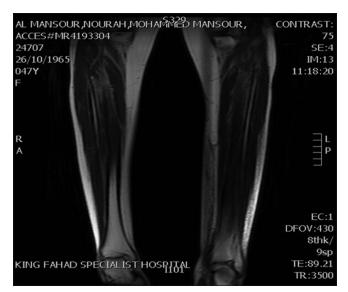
Magnetic resonance imaging tibia/fibula left with cellulitis and small abscess at lateral aspect necrotizing fasciitis
